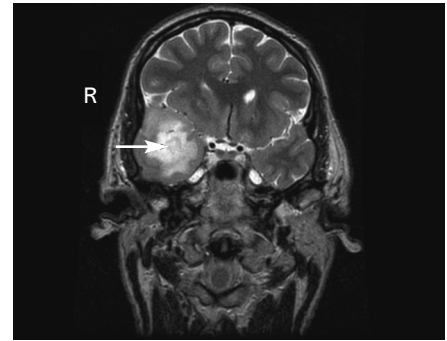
Magnetic resonance imaging scan of head. The tumour is in the right temporal lobe.
